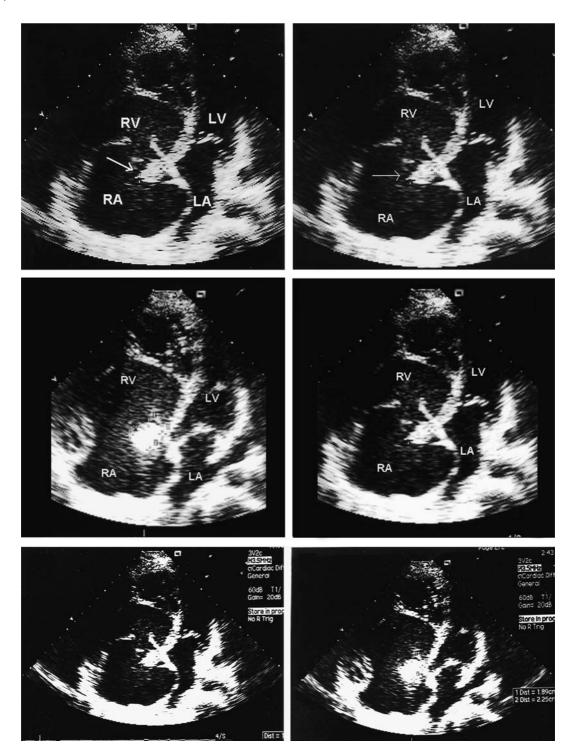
Apical four-chamber transthoracic echocardiography shows dehiscence of patch (arrow) which mimics vegetation. Bulging of the atrial septum towards the left side as a sign of pulmonary hypertension is also seen.
